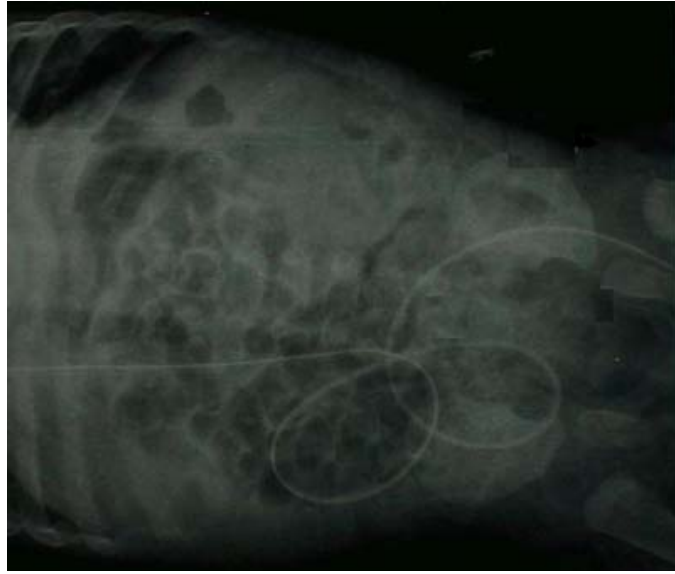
Distal migration of shunt catheter into scrotum, AP X-ray imaging
